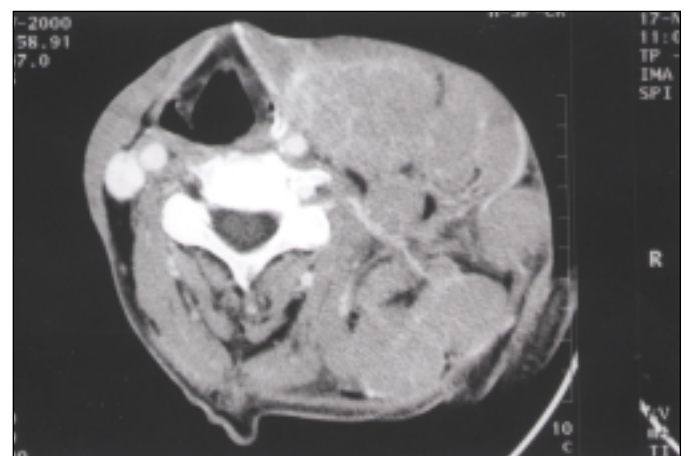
CT scan of the neck with identification of multiple bulky, homogenous nodes involving the left neck.
